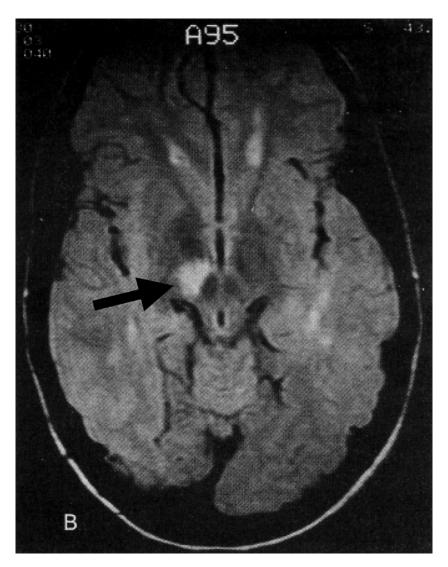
Axial fluid-attenuated inversion-recovery sequence magnetic resonance image of a 24-year-old woman with multiple sclerosis demonstrating a plaque (arrow) in the area of the right subthalamic nucleus. (Reprinted with permission from ref. *15*.)
